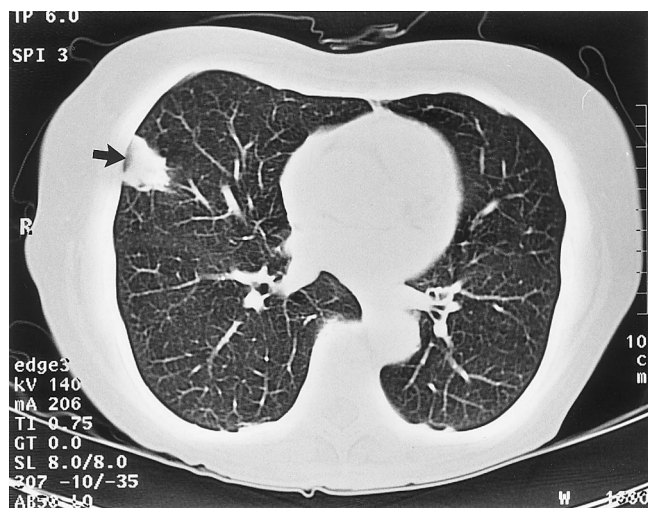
CT scan at the level of the middle lung lobe showing a $2.5 \times 2.5 \times 2.0$ -cm solid lesion located subpleurally, without calcification or necrosis (arrow) and with normal lung parenchyma.
